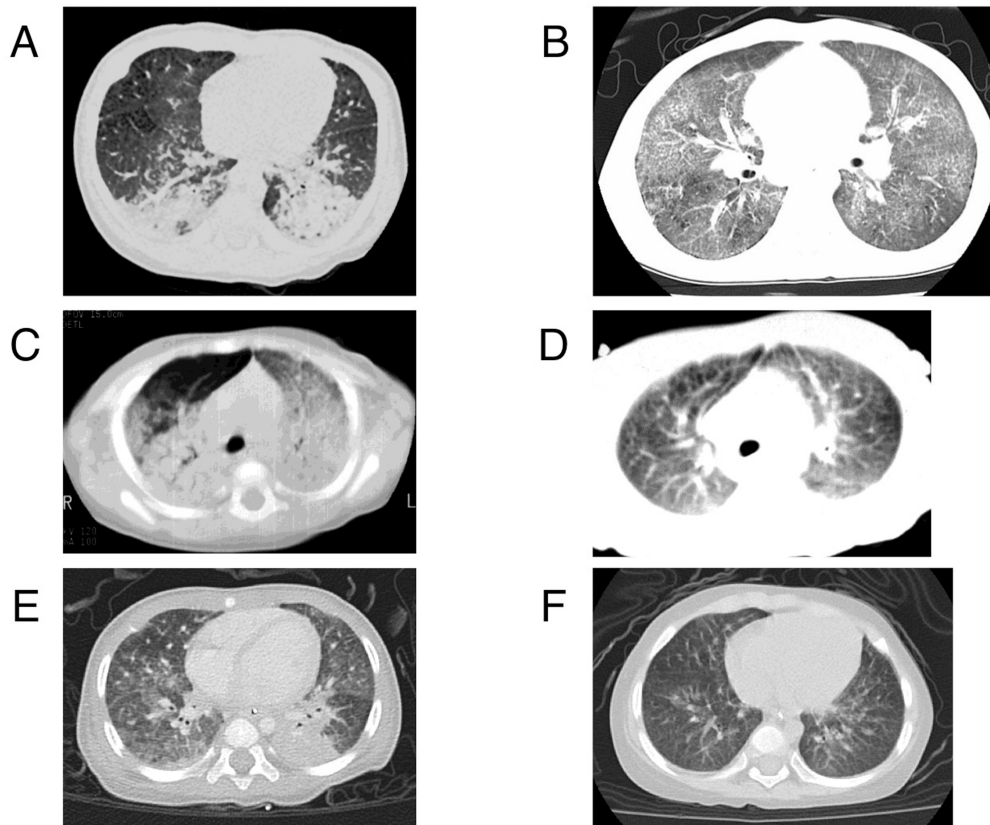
Chest CT findings
